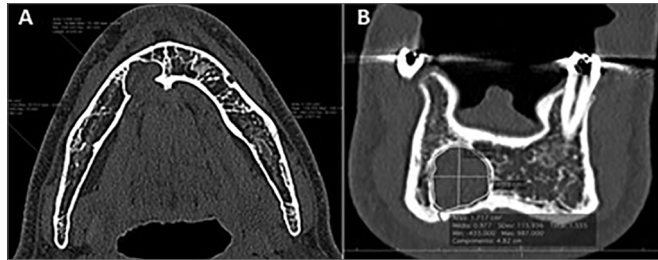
Multislice computed tomography. (A) Axial section showing a lingual bone defect with a slight reduction of the buccal cortical plate and defined corticated margins. Note the value of 19.866 HU for the content compared with the fat areas (-8 HU) adjacent to the lingual cortical plate of the mandible in the posterior region. (B) Coronal section. Observe the extensive bone defect confined to the medullary portion of bone, preserving the base of the mandible.
